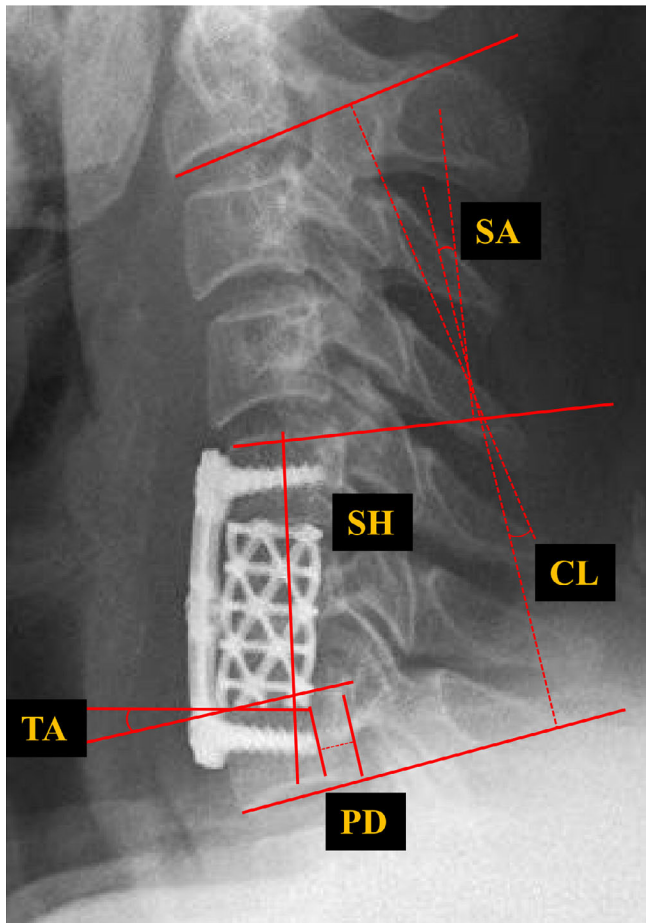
Radiographic evaluation of TMC position. Cervical lordosis (CL): the angle formed between C2 and C7 lower endplate. Segmental height (SH): the distance between the midpoint of the superior endplate of the upper vertebral body and the midpoint of the inferior endplate of the lower vertebral body. Segmental angle (SA): the angle formed between the superior endplate of the upper vertebral body and the inferior endplate of the lower vertebral body. TMC tilt angle (TA): the angle formed between the lower plane of the titanium cage and the level of the upper endplate of the inferior vertebral body. Placement depth (PD): the distance between the posterior edge of the titanium cage and the posterior edge of the vertebral body.
